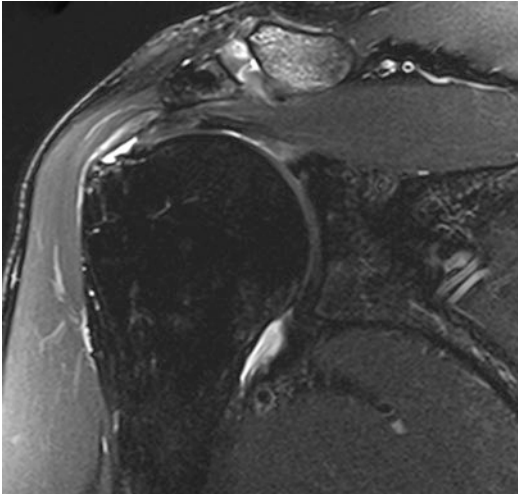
MRI of a shoulder with a complete rotator cuff tear (m. supraspinatus)
